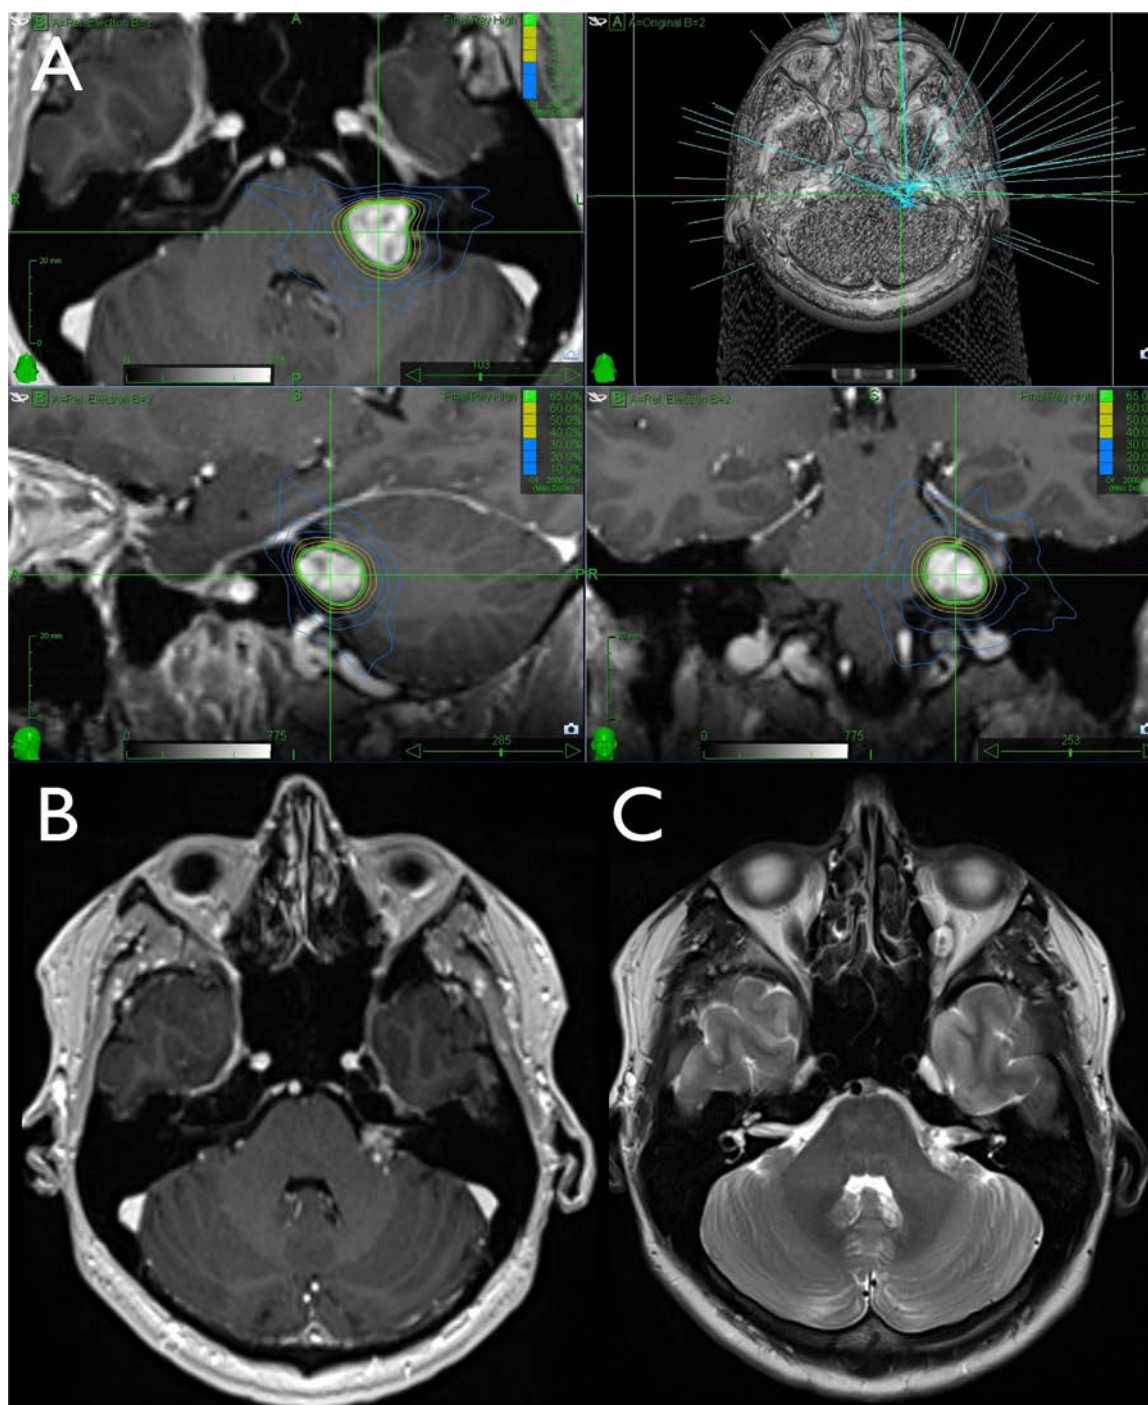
(A) Treatment plan for a left vestibular schwannoma. Single-fraction stereotactic radiosurgery, prescription dose 13 Gy, prescription isodose line 65%, planning target volume 1.83 cm³. (B/C) Magnetic resonance imaging, T1-weighted contrast-enhanced (left) and T2-weighted images (right), 17 months after treatment, demonstrating treatment response and loss of contrast enhancement.
